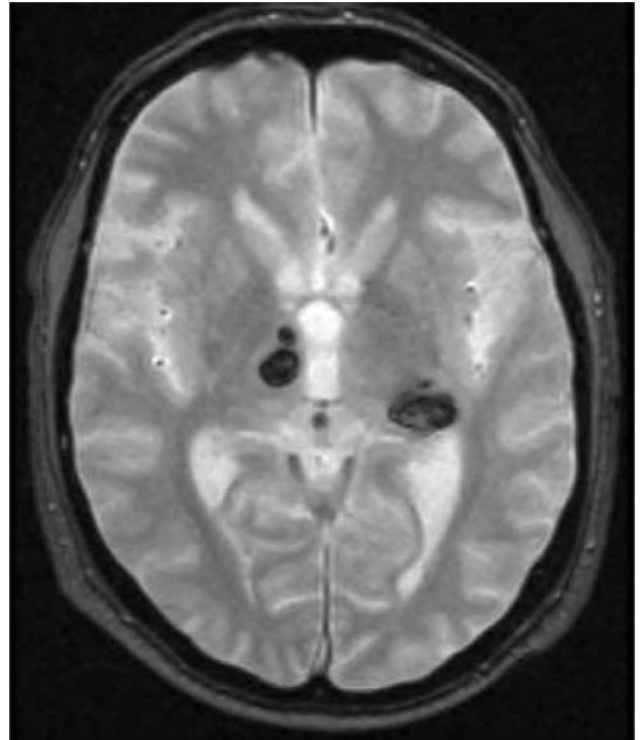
Axial T2 gradient-echo MRI 24 hours after the procedure shows bilateral thalamic hemorrhage.
